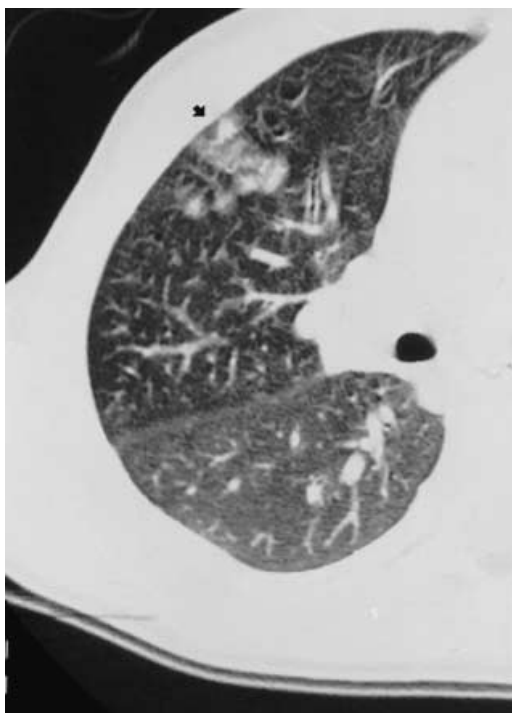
High-resolution CT of patient no. 2. Confluent nodules realizing a patchy ill-defined area in the middle lobe (*large arrow*). Bronchial wall thickening and ground-glass opacities are present in the lower lobe
